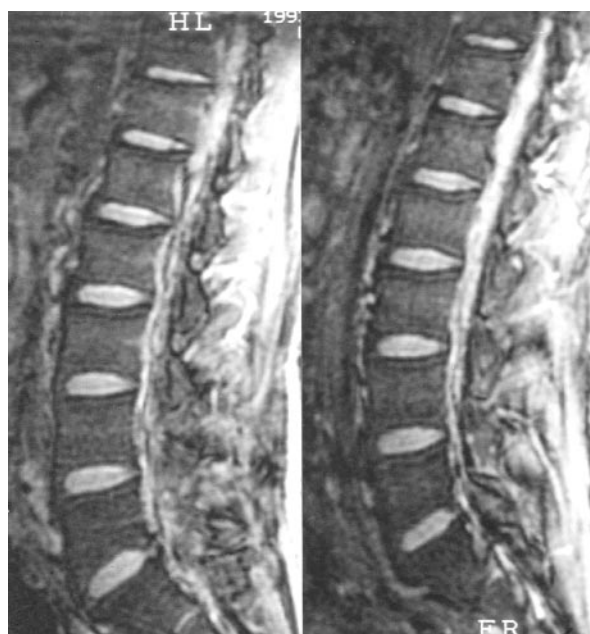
Magnetic resonance imaging scans of a patient with chronic postthrombotic pelvic venous obstruction. Parasagittal magnetic resonance images of the lumbosacral region were obtained from a patient who experienced iliofemoral thrombosis 11 years earlier and suffered from symptoms of a narrow spinal canal since then. Dilated and slightly tortuous veins are present in the spinal canal. Stenting of the completely occluded pelvic axis was not feasible.
